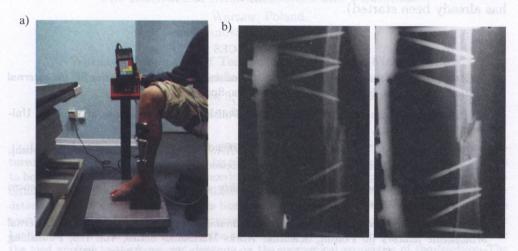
a) A patient in the process of determining the bone-union measures (the load  $F_z$  is read on the electronic-balance display; the value of the load carried by the bearing frame in the fixator is measured by a strain gauge system and stored in the computer). b) X-ray picture of fractured bone with the DYNASTAB DK Fixator installed; the characteristic spatial configuration of bone screws can be seen.
